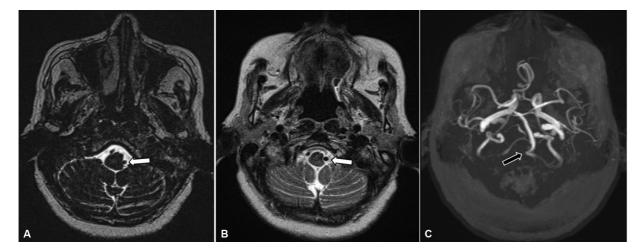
T2-weighted axial (A), coronal (B), and sagittal (C) image sections showing dominant and angulated V4 segment of the left vertebral artery flow void indenting the anterolateral aspect of the medulla on the left side
